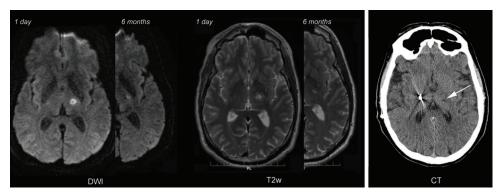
Neuroimaging of Neurosurgical Procedures for Tremor. Brain MRI of a tremor patient 1 day and 6 months after MRgFUS-thalamotomy of the left hemisphere (right). CT scan of another tremor patient who underwent left RF-thalamotomy (arrow) followed by right Vim-DBS (left). DBS, Deep Brain Stimulation; DWI, Diffusion-weighted Imaging; MRgFUS, MRI-guided Focused Ultrasound (of Vim); RF, Radiofrequency; T2w, T2-weighted Imaging; Vim, Ventrointermedius Nucleus of the Thalamus.
